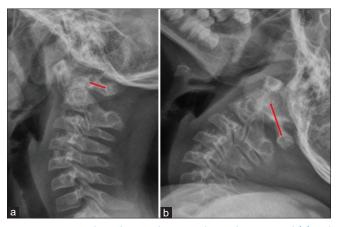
Dynamic lateral cervical spine radiographs in neutral (a) and extension (b) views, showing reduction of the atlantoaxial dislocation on extension (b), with a corresponding increase in the diameter of the spinal canal as denoted by the solid red line
